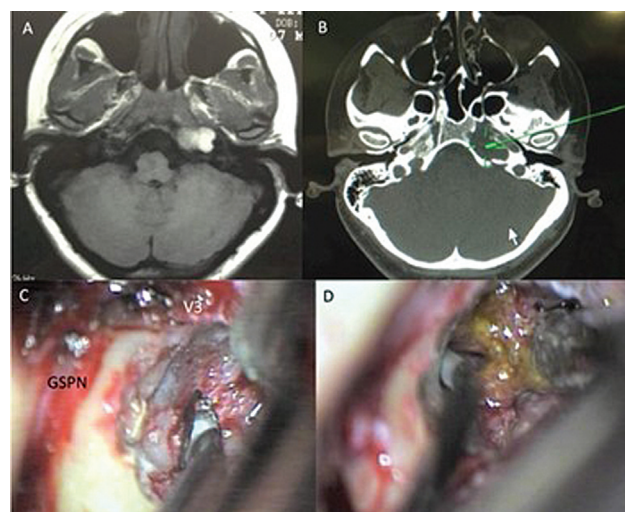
Cholesterol granuloma of the petrosal apex. (A) axial T1 weighted showing high signal image; (B) axial head bone window computed tomography showing bone erosion of the petrosal apex; (C) intraoperative anterior petrosectomy in-course; (D) exposed tumor.
